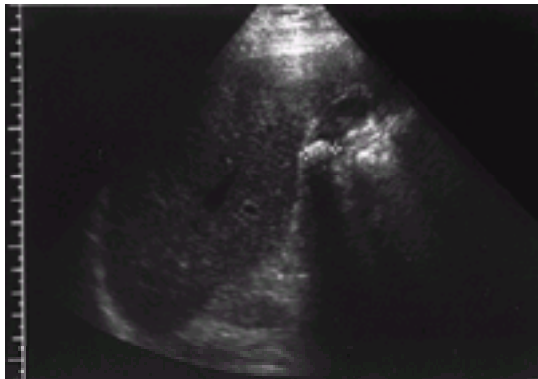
Ultrasonogram showing gallstones in a contracted, thick-walled gallbladder.
